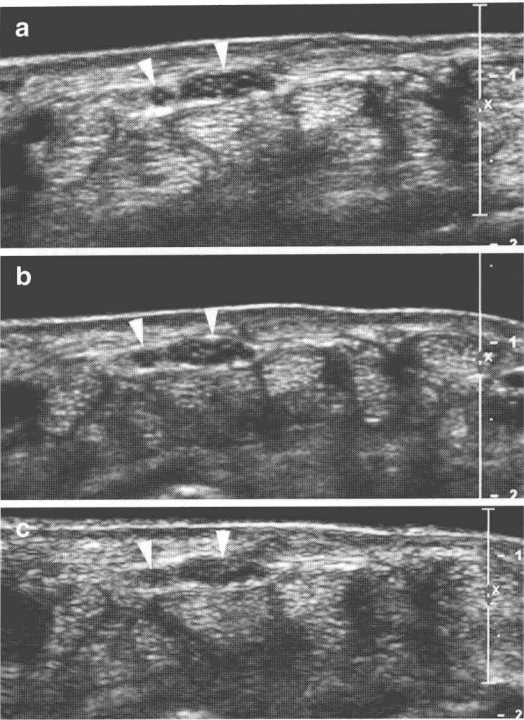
Transverse ultrasound images through bifid median nerve (*arrowheads*) in a healthy volunteer taken with a 17 MHz (a), 12 MHz (b), and 9 MHz (c) transducer (all images taken on a Philips IU22 under the same preset). Note the difference in the discrimination of the fascicular nerve structure. In (c) the inner structure of the nerve is barely defined
